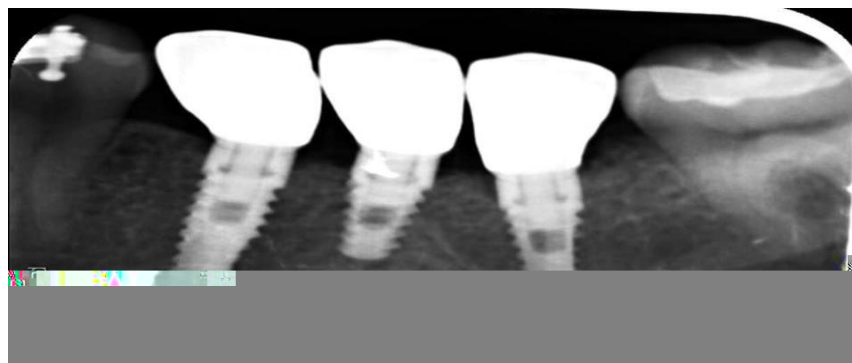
Retroalveolar roentgen control image after 12 months
